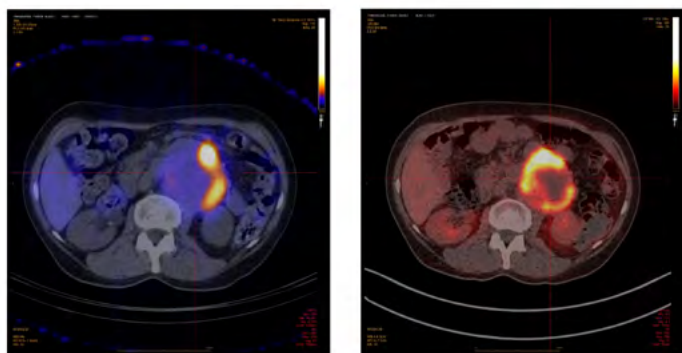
Different metabolic information provided by $^{123}\text{I-MIBG}$ SPECT/CT (left panel) and $^{18}\text{F-FDG}$ PET/CT (right panel) in a paraganglioma. A “flip-flop” phenomenon of heterogeneity of metabolism in a centrally necrotic tumour (areas less active on $^{123}\text{I-MIBG}$ are more active on $^{18}\text{F-FDG}$ and vice versa).
